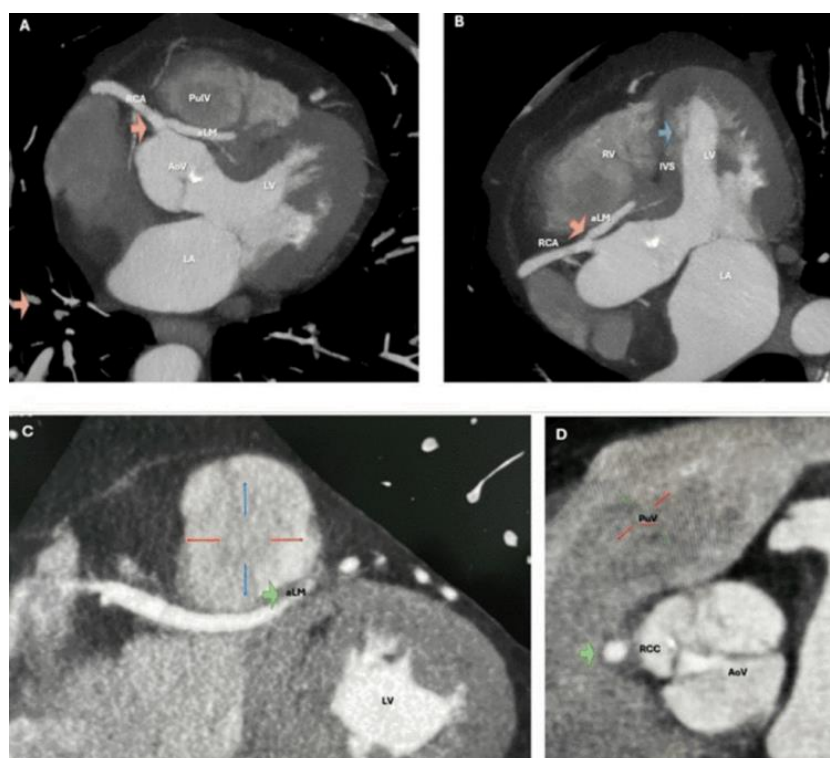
Cardiac CTA performed to exclude intracardiac embolic. On figure 1A, 1C, and 1D the LM and RCA share a common ostium (orange arrow) with LM running through a caudal course towards the pulmonary valve. On figure 1B, demonstrates a focus of fat-equivalent hypoattenuation in the interventricular septum, most consistent with intramyocardial fat (blue arrow).
